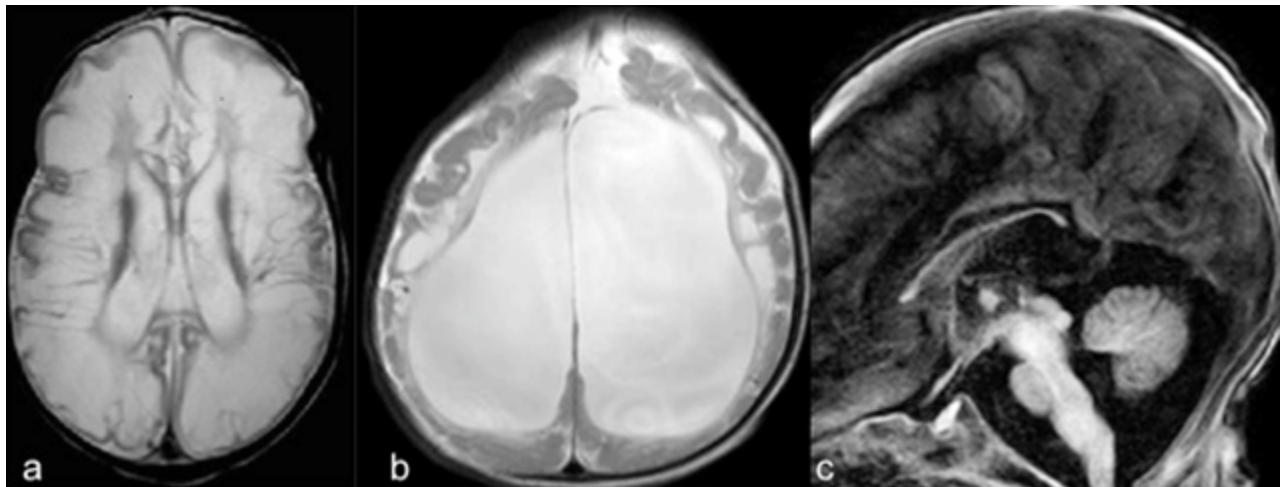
Brain MRI in a child with classic isolated sulfite oxidase deficiency
